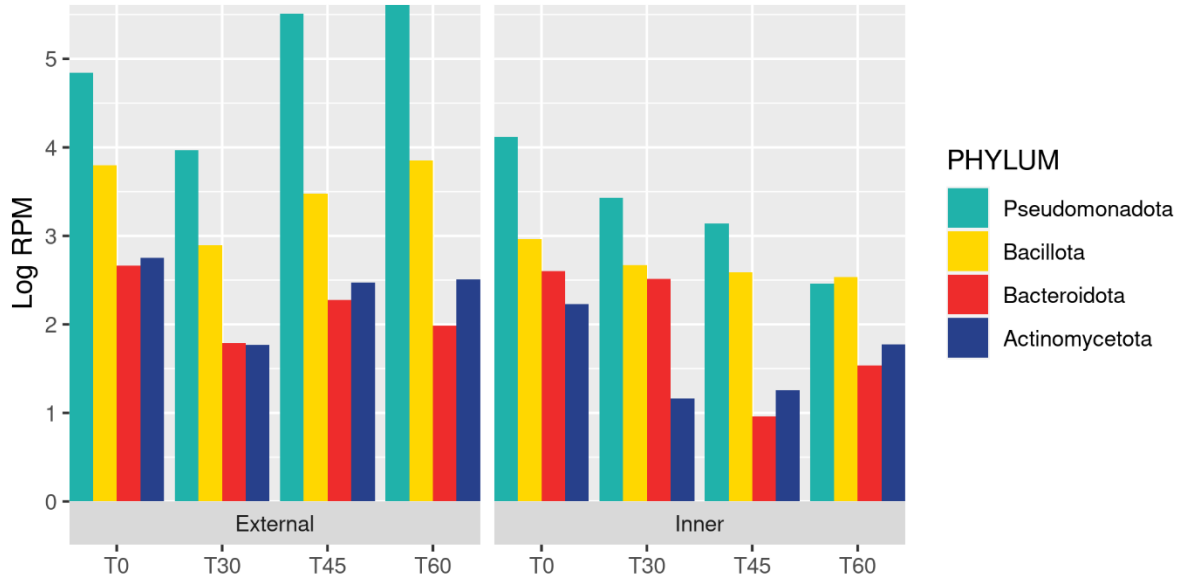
Graphical representation of the composition of the external and internal composition of the Angus samples (CT) at the phylum level.
